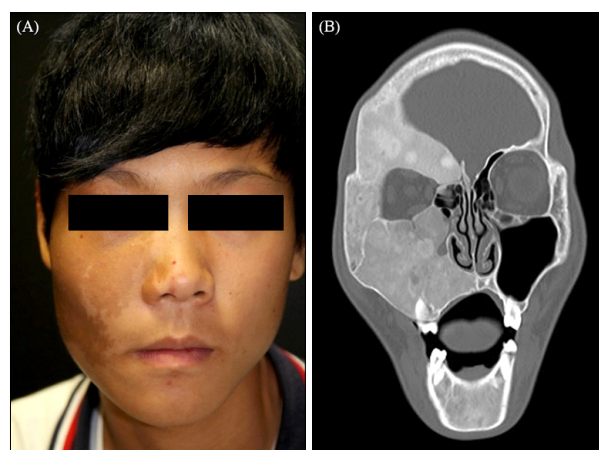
(A) Solitary, brown patch with irregular border, throughout the patient's right cheek and upper eyelid with facial asymmetry. (B) Coronal computed tomography scan demonstrates heterogeneous ground glass appearance at the right anterior skull, consistent with polyostotic fibrous dysplasia of the skull, right maxilla and mandible and narrowing of superior and inferior orbital canal, and compressing the right optic nerve.
